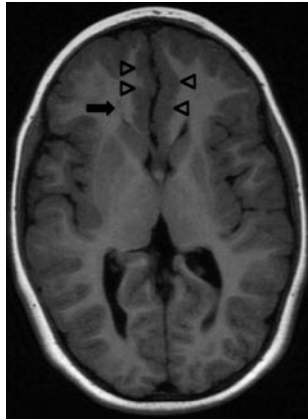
Axial T1-weighted inversion recovery (TR/TE/T1, 2448/9/750) image of a 6-year-old boy with septo-optic dysplasia shows right periventricular heterotopia (*small arrow*) and a bifrontal cortical malformation (*arrowheads*), very similar to the appearances shown by Bergson, Garg, and Chang. Septal agenesis and ectopic posterior pituitary lobe were also present (not shown).
